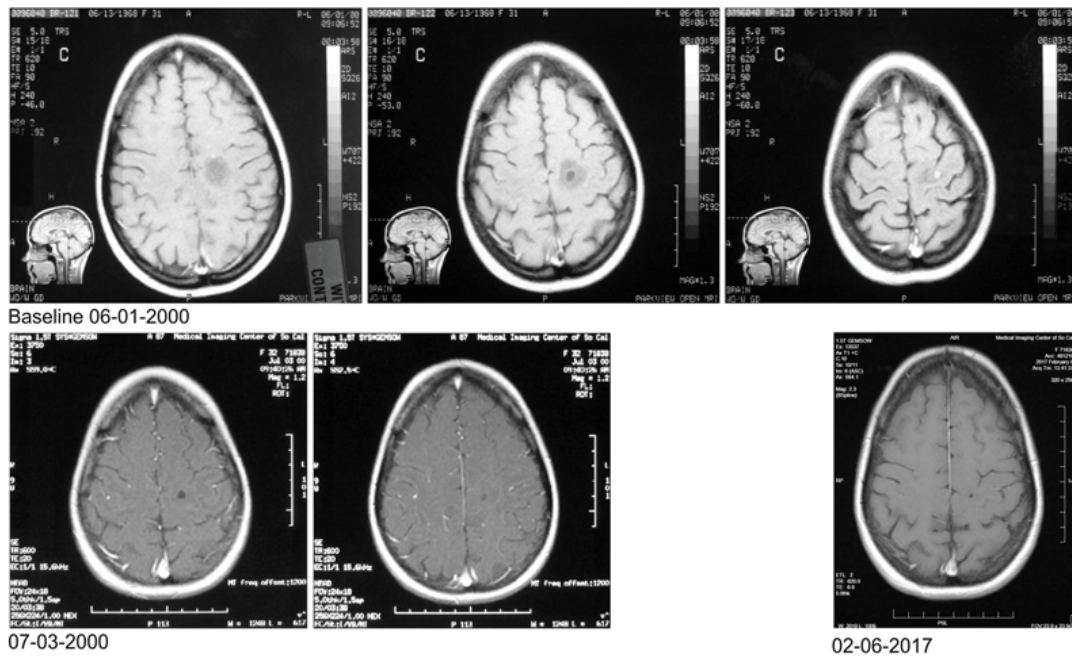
Axial MRI Images: 06-01-2000: this baseline set of images, in each instance, shows a 2.0 cm² non-enhancing nodule in the left parietal lobe while the left-sided image shows a 0.15 cm² enhancing nodule situated anteriorly and the right-sided image shows a 0.20 cm² enhancing nodule situated medio-laterally; 07-03-2000: there is disappearance of the enhancing nodules in the left parietal lobe, indicating a CR, while the non-enhancing nodule persists; 02-06-2017: there is complete disappearance of the 2.0 cm² non-enhancing nodule in the left parietal lobe and the two enhancing nodules indicating an enduring CR and complete disappearance of all tumor. CR=Complete response; MRI=magnetic resonance imaging.
